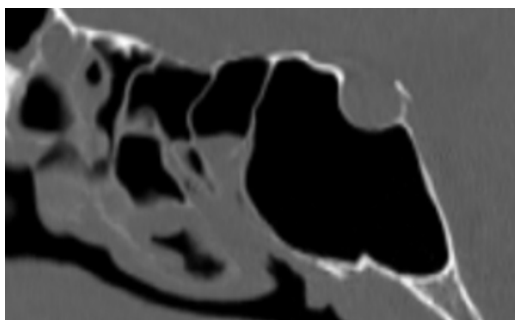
Sagittal CT slice of the sphenoid sinus, bone window, demonstrating the absence of septa
